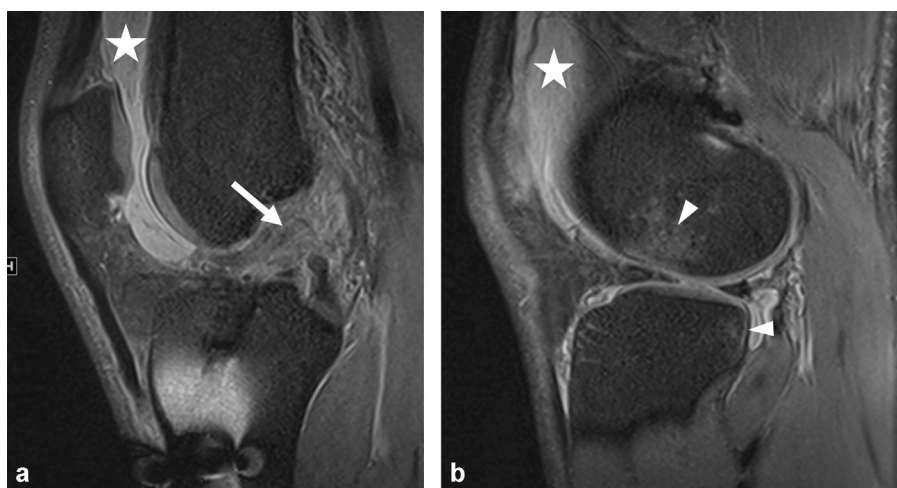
Recent trauma-induced graft tear. Sagittal fat-suppressed PD-weighted MR image. Hyperintense signal and heterogeneity of graft fibers (arrow). Articular effusion (star). Osseous defect at the anterior part of the lateral femoral condyle and the posterior part of the lateral tibial condyle (arrowheads) indicating recent sprain with anterior drawer mechanism.
